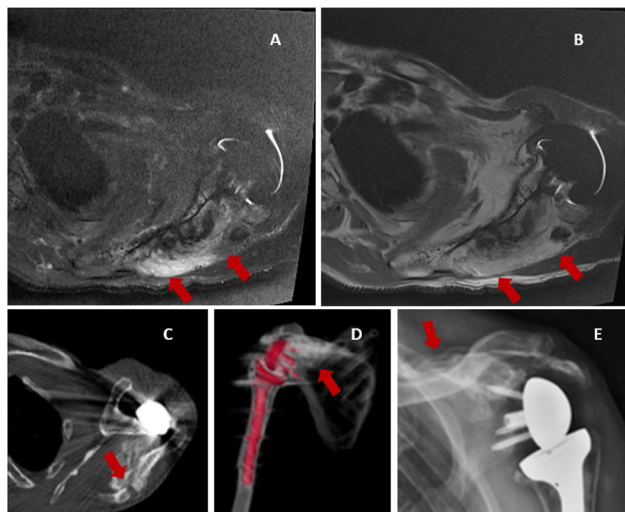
MRI images of the ASFs with exuberant periscapular bone proliferation surrounding the fracture line (A–B); CT images of left ASF with non-union (C–D); X-ray images of fracture consolidation one year after (E).
